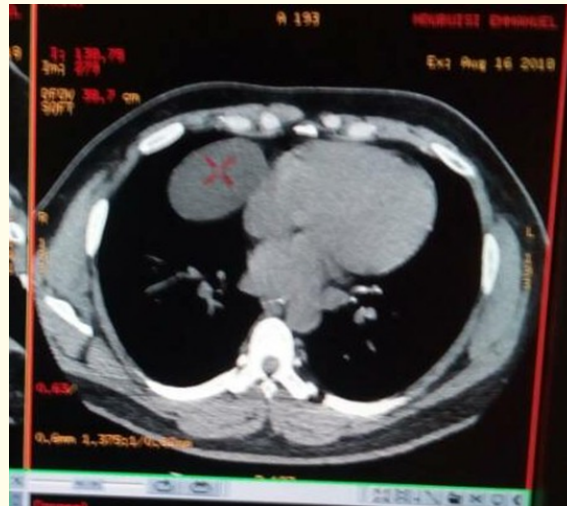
Cyst assessment with a contrast chest CT.
